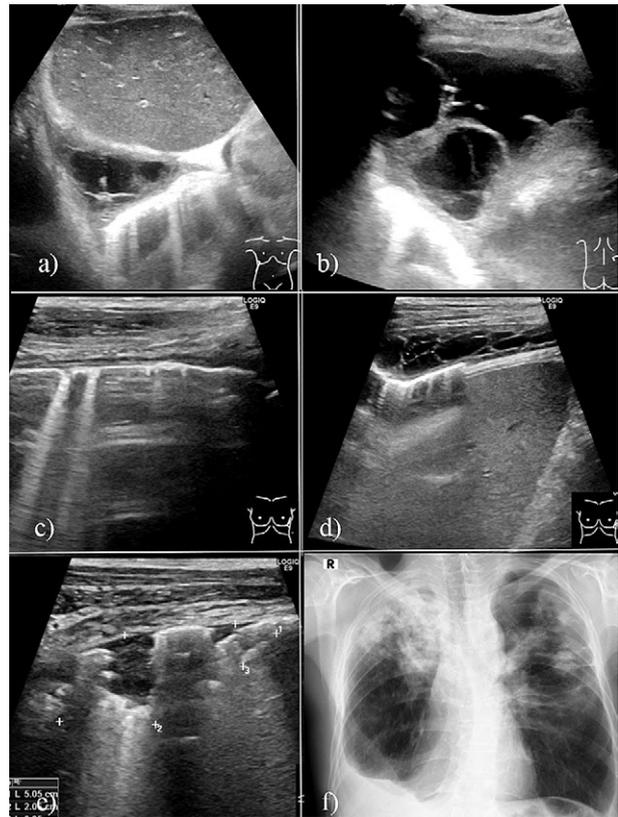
a) and b) Right pleural collection. Gray scale examination focused on the right hypochondrium using the liver as acoustic window (a) and the base of right hemithorax (b). In both incidences a moderate amount of fluid may be seen, with a relatively transonic aspect (suggesting fluid consistency), septa (possibly secondary to abundant fibrin content) and marked thickening of parietal, visceral and diaphragmatic pleura; c) Left pleural thickening; d) Fluid accumulation and septa; e) gray scale examination focused on the right anterior hemithorax (subclavicular). Discontinuities of the pleuro-pulmonary surface. Area of parenchyma condensation (hypoechoic) and small amount of fluid between pleura sheets; f) X-ray examination. Lung caverna – right apex. Bilateral pleural effusions.
